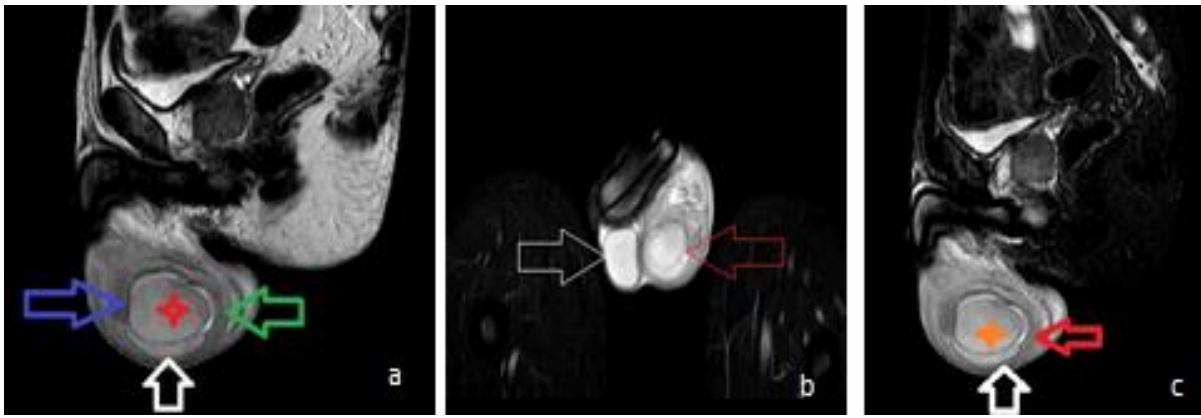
MRI images contd. (a) T1WI sagittal section of left scrotum shows hypointense left testis (red star) with minimal hydrocele (white arrow) thickened tail (green arrow) and head (blue arrow) of the epididymis. (b) coronal STIR section of the scrotum shows less intense signal from left testis (red arrow) as compared to right testis (white arrow). (c) STIR sagittal section shows hypointense testis (saffron star) with thickened wall (red arrow) and minimal collection (white arrow).
